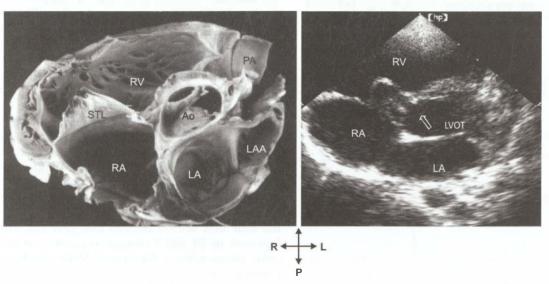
Echocardiogram (right frame) with anatomic correlates (left) in membranous ventricular septal defects. This view is a parasternal short axis view. An aortic root; LA left atrium; LVOT left ventricular outflow tract; RA right atrium, RV right ventricle; arrow points to the VSD that is partly closed by aneurysm of the septal leaflet of the tricuspid valve
